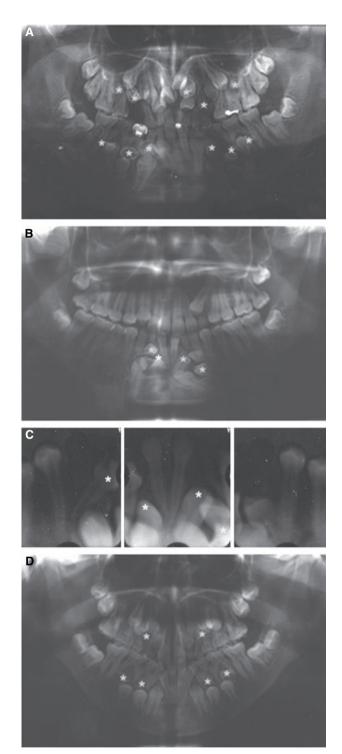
Panoramic X-rays of III:1 (A: 17-year-old male), III:2 (B: 15-year-old female) and III:3 (D: 12-year-old male). Dental X-rays of the mandibular incisal regions are shown to highlight the exact numbers of supernumerary teeth in III:2 (C). Note the different position and number of supernumerary teeth among the three siblings. Each asterisk denotes a supernumerary tooth.
